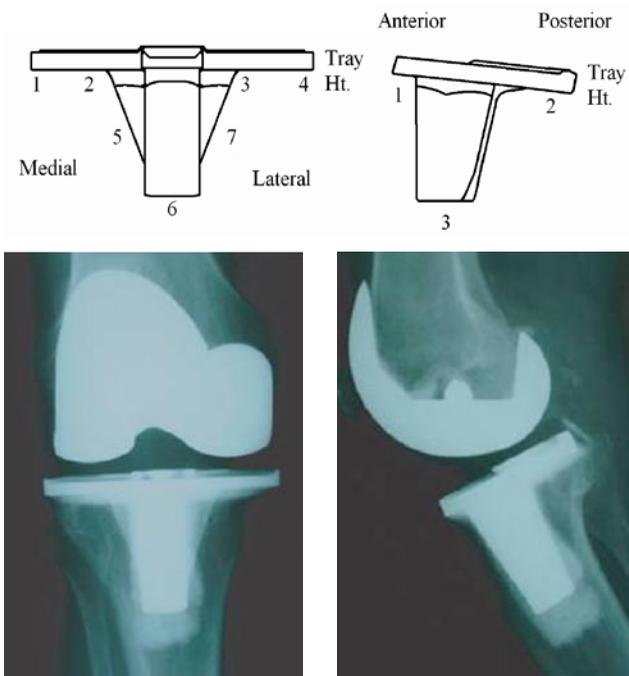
At 6 weeks, cement mantle depth penetration measurements were made in zones numbered in anteroposterior and lateral views of tibial tray (top row). Total area of cement mantle was also assessed from radiographs. Representative patient's radiographs are shown for comparison.
